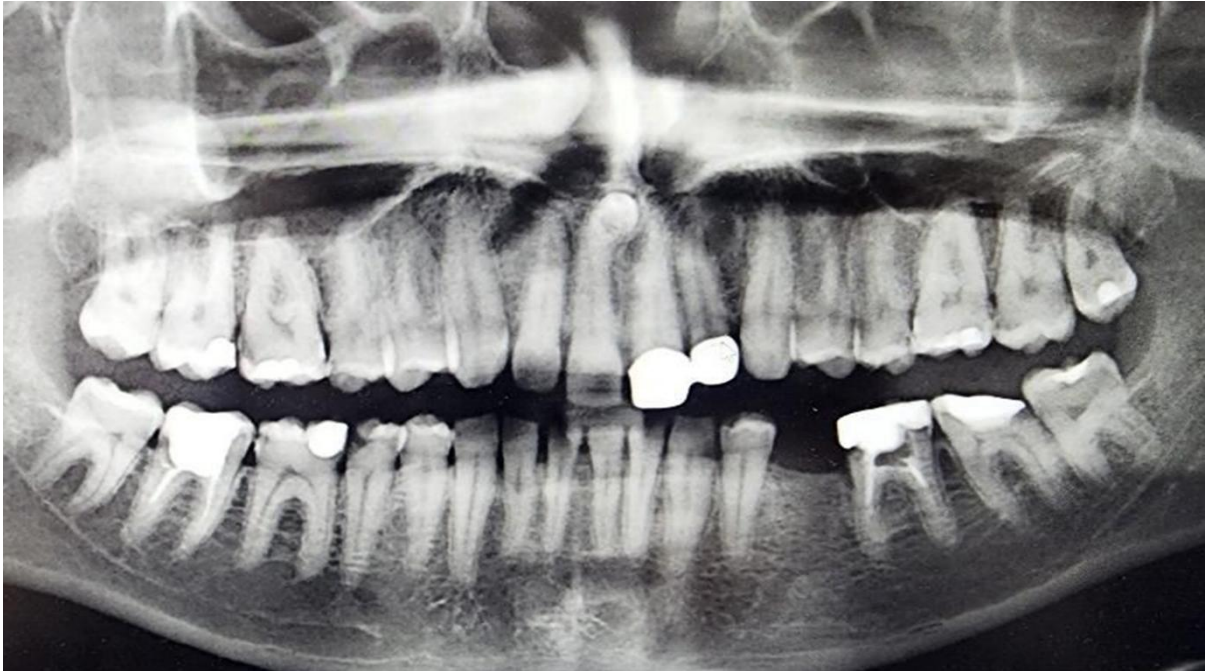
Preoperative panoramic radiograph demonstrating compromised dentition and inadequate previous treatments.
